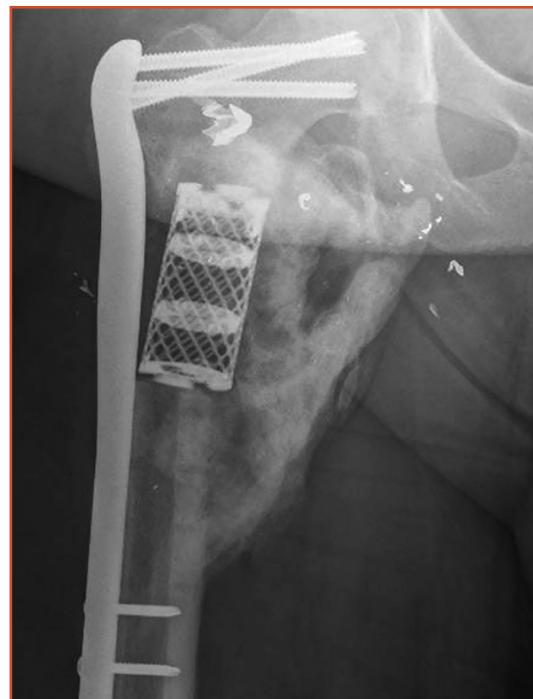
At 3 months after revision open reduction and internal fixation, radiograph shows anteroposterior view of the right hip with a titanium mesh cage and proximal femur locking plate.
